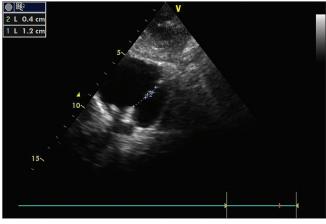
A subcostal transthoracic echocardiographic view showing the two-hole atrial septal defect separated by a small portion of the septum
